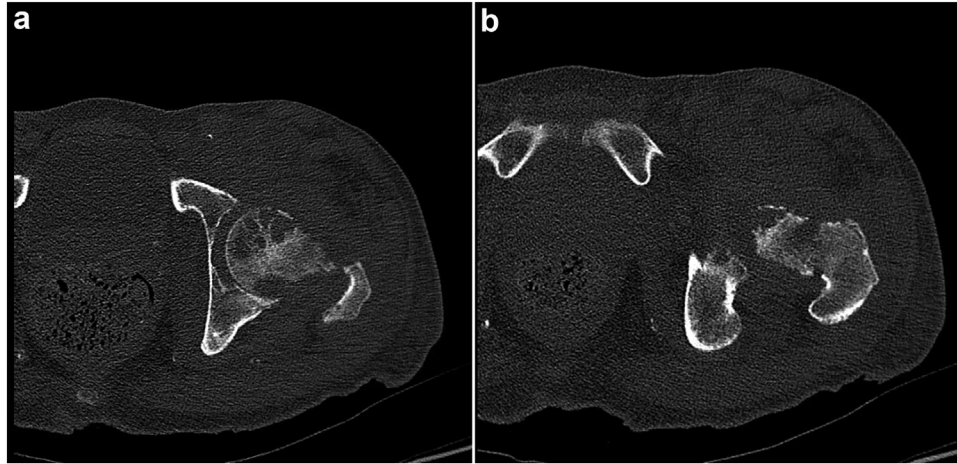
Preoperative CT scan. Axial cuts of the left femoral head (a) and neck (b) demonstrating extensive periarticular erosions and lytic lesions of the proximal femur, concerning for impending fracture.
